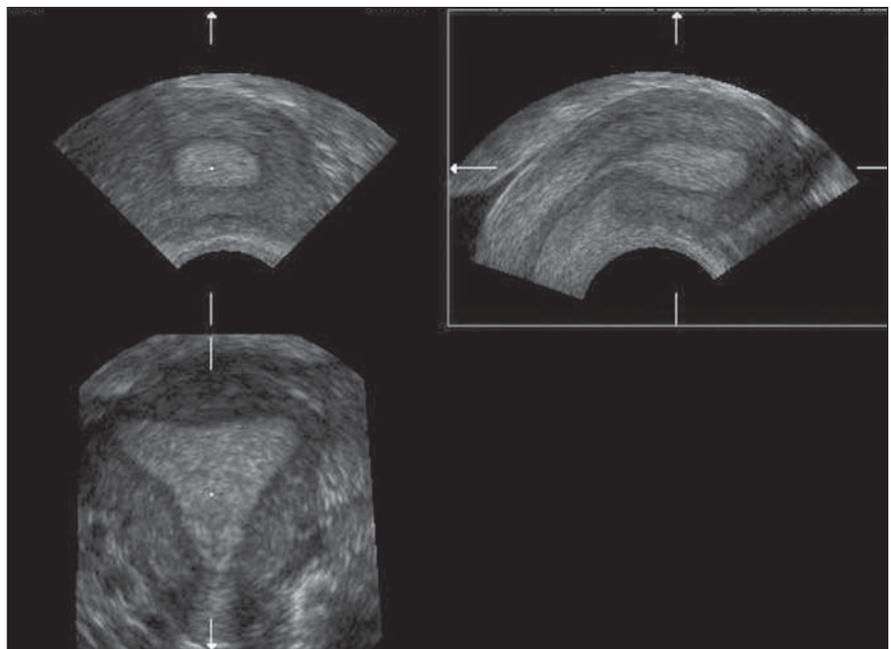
Normal uterus on 3D multiplanar ultrasound. Observe the secretory pattern of the endometrium on the three views.
